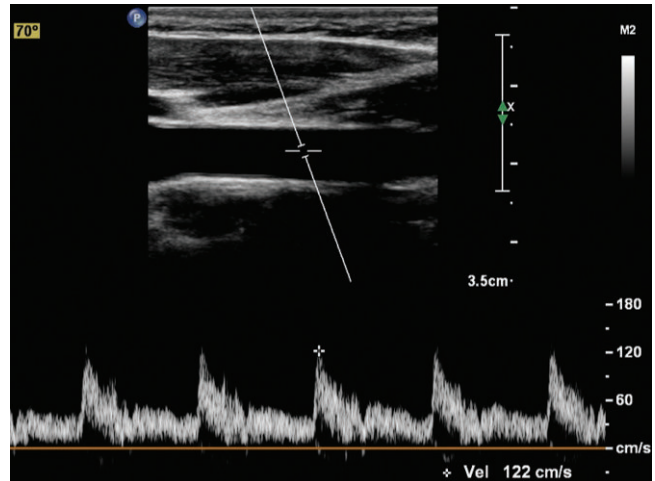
Spectral Doppler angle correction is incorrect. The vessel is at too high an angle (70 degrees) for an acceptable measurement. Note the large difference between 60 degrees, 122 versus 92 cm/s.
